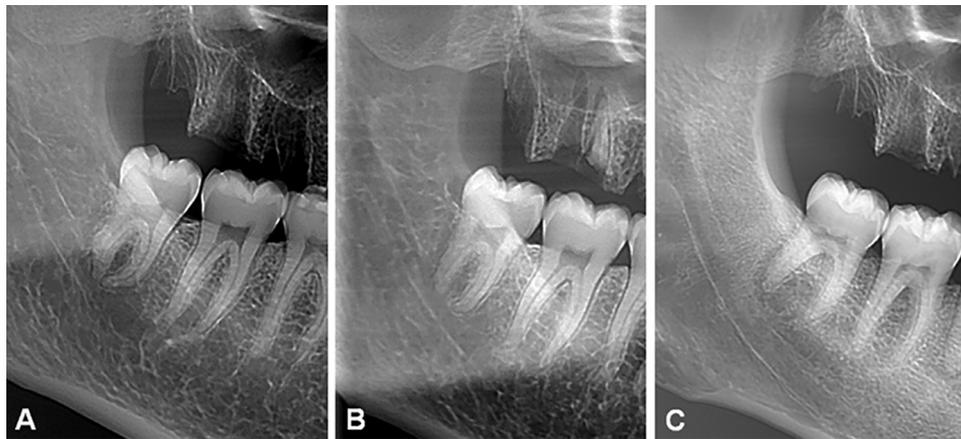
Cropped images of panoramic radiography (PAN) showing the mesiodistal relationship between the second and third molars, classified as “distant” (A); “in contact” (B); and “overlapped” between the proximal surfaces (C).
